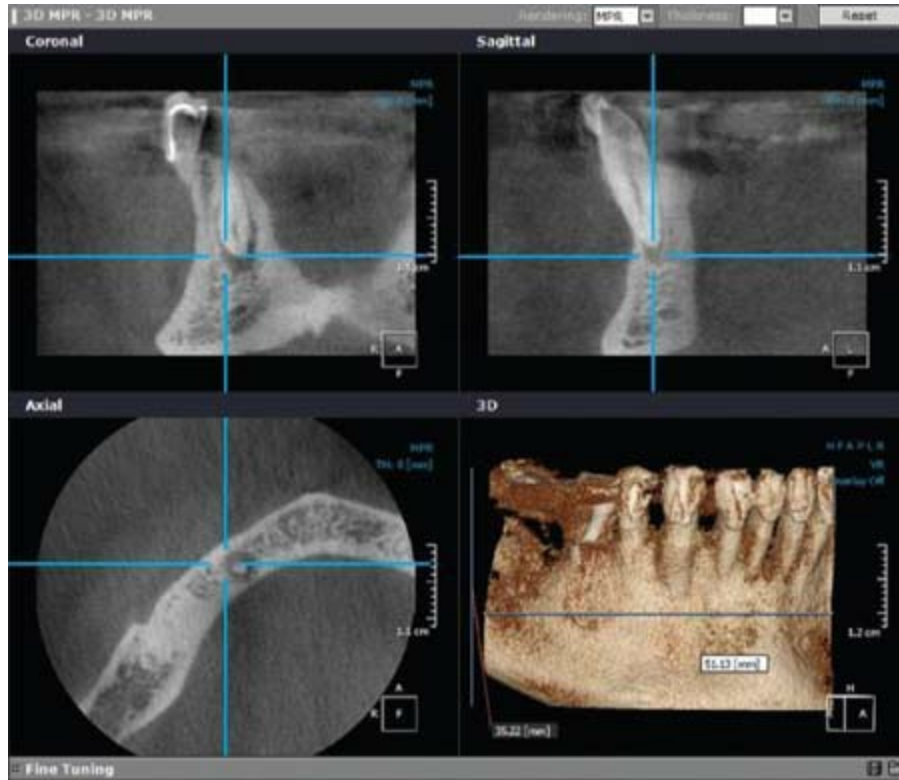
Multiplanar and 3D color reconstructed views of the mandibular quadrant taken on a CBCT machine with a volume size of 37 × 50 mm.
